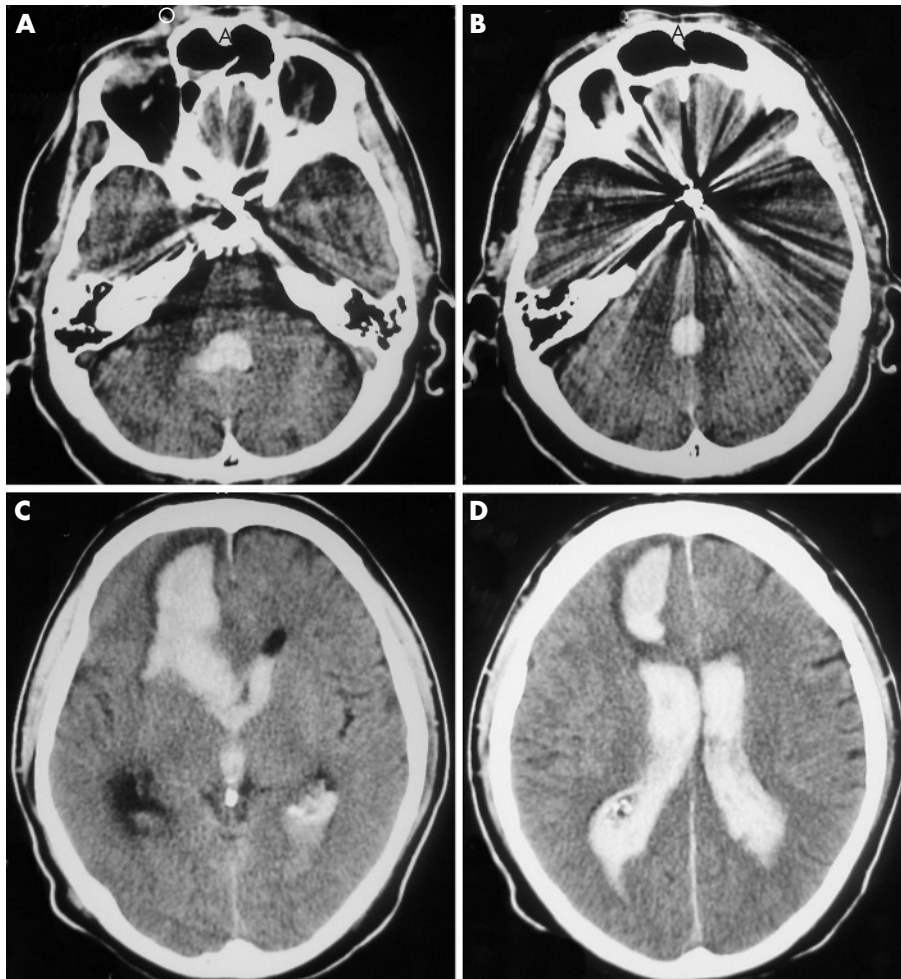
Pre-operative computed tomography scan showing haematocephalus from rupture of the anterior communicating artery (AcoA); coils are evident in (B) (patient 7).
